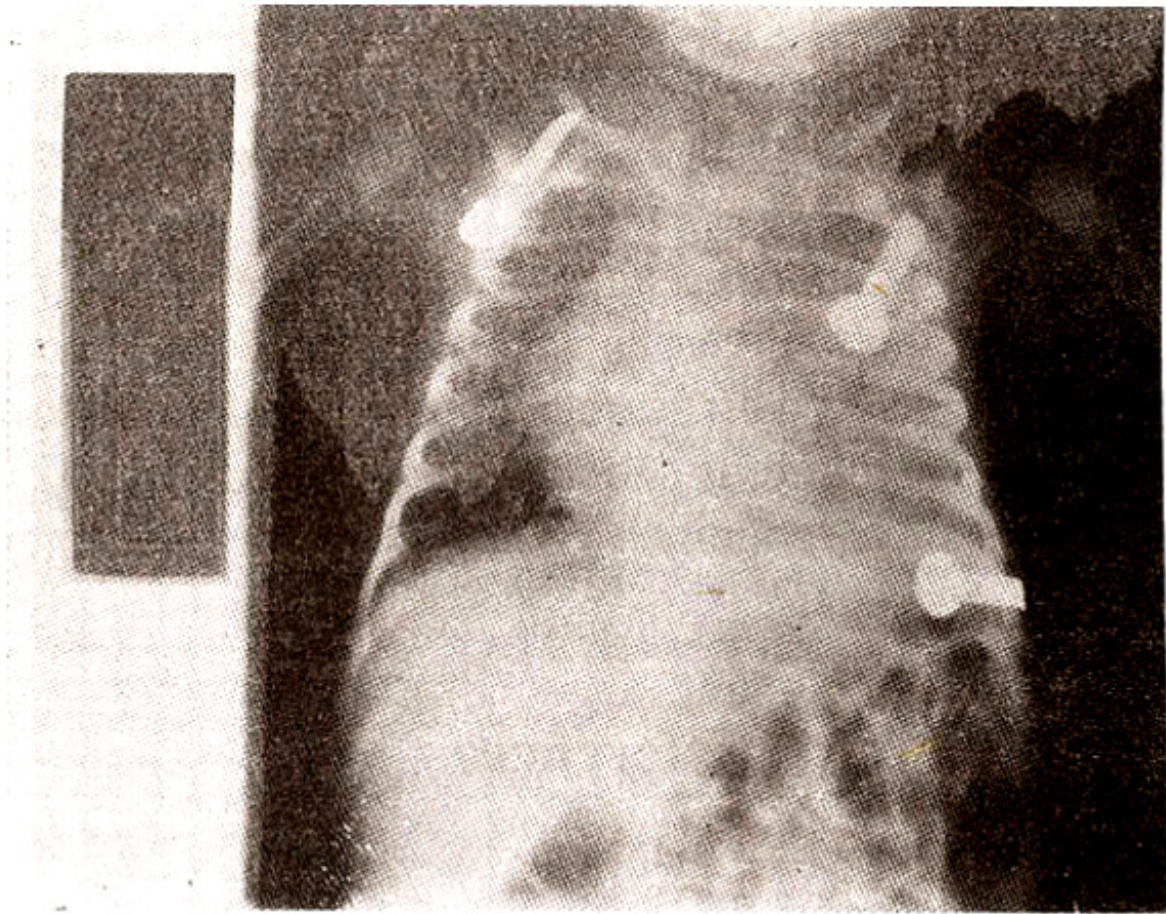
Chest radiograph showing complete consolidation of the left lung with pleural effusion.
